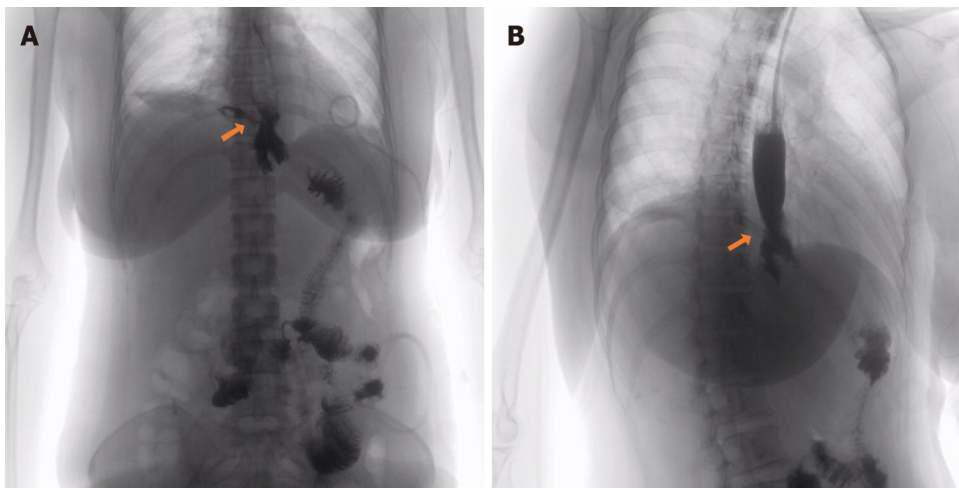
Postoperative anastomosis computed tomography image. A: Computed tomography (CT) on postoperative day 6 showed changes consistent with postoperative gastrointestinal tract. The red arrow showed the position of the anastomosis; B: CT on postoperative day 13 showed anastomosis at the lower end of the esophagus. Red arrow showed the cystic air-containing cavity in the right mediastinum appears to be connected to the anastomosis and the possibility of an anastomotic fistula is considered.
